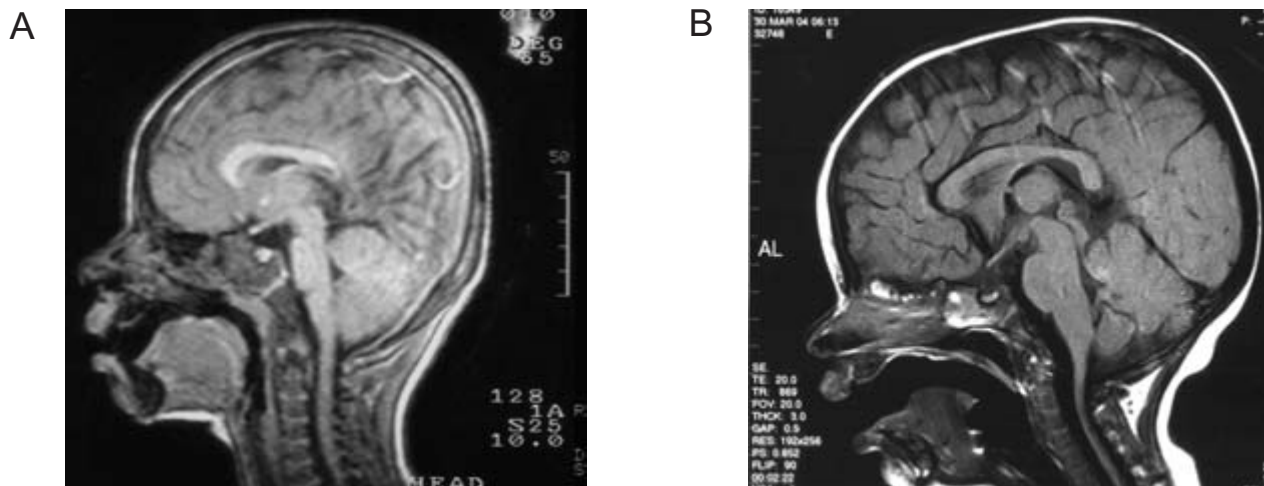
(A) Patient no. 4. Sagittal T1-weighted image. Partial callosal agenesis: absence of splenium of the corpus callosum. (B) Sagittal T1-weighted image of a normal corpus callosum.
